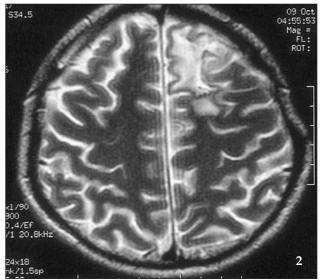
Preoperative, T1- (1) and T2-weighted (2) magnetic resonance imaging scans, showing the craniotomy defect and encephalomalasia at the left frontoparietal area.
